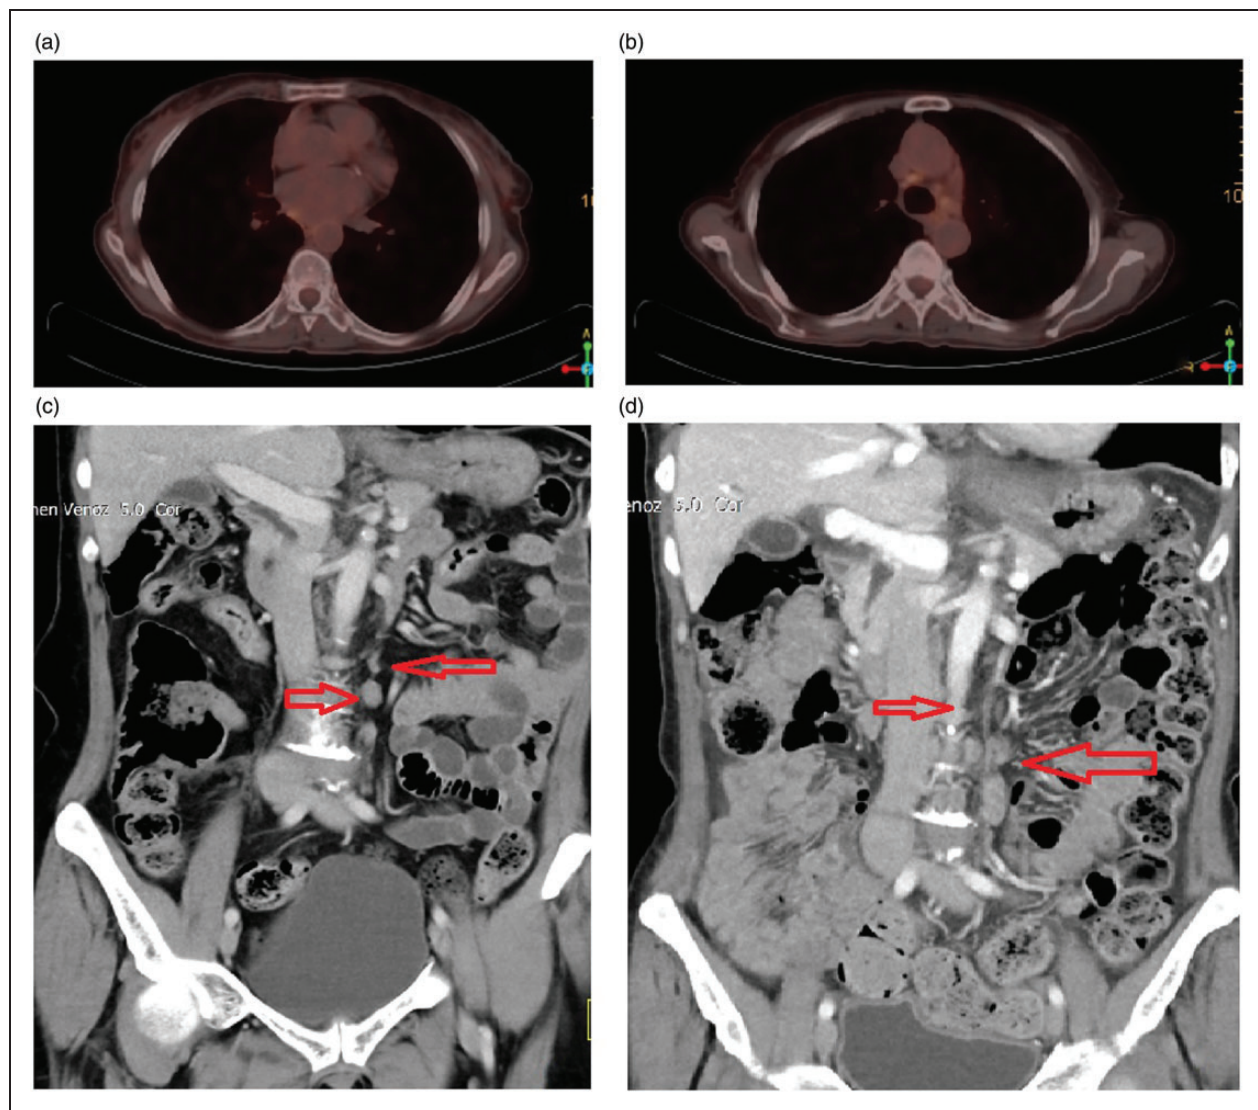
In the F18 FDG-PET/CT examination dated March 2020; It is seen that the mass observed in the right hilar region has disappeared (a). In the same examination, aortopulmonary, paratracheal lymph nodes appear to be persistent, although their size decreases (b). On CT images with coronal reformat; enlarged lymph nodes with paraaortic size, the largest of which are 20x11 mm in size, and their numbers remain stable (c, d).
